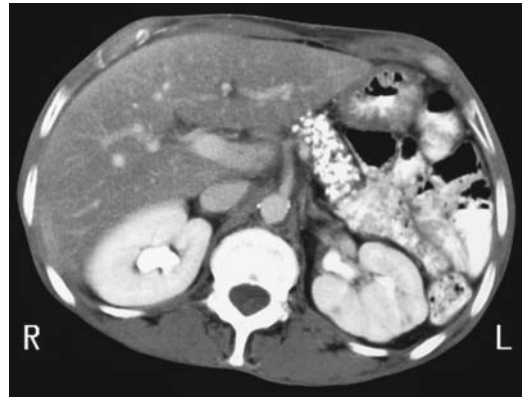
Chronic pancreatitis. Computed tomography reveals extensive calcifications that have replaced most of the pancreatic parenchyma. (Courtesy of Patrick Fultz, M.D., University of Rochester.)
